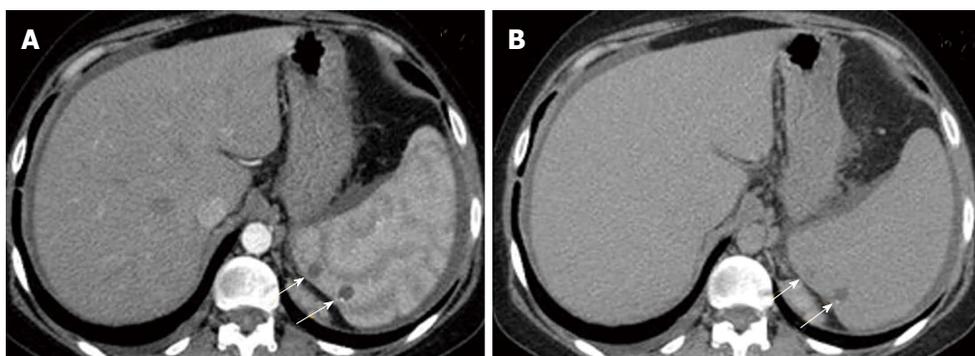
Triphasic post contrast axial computed tomography showing. Multiple splenic hemangiomas in portal (A) and delayed (B) phases respectively showing filling in (arrows).
